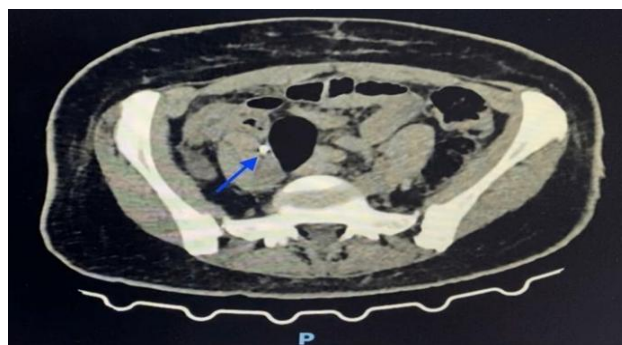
CT scan of the pelvis shows a moderate collection of liquid on the pelvis (marked by the blue arrow).
